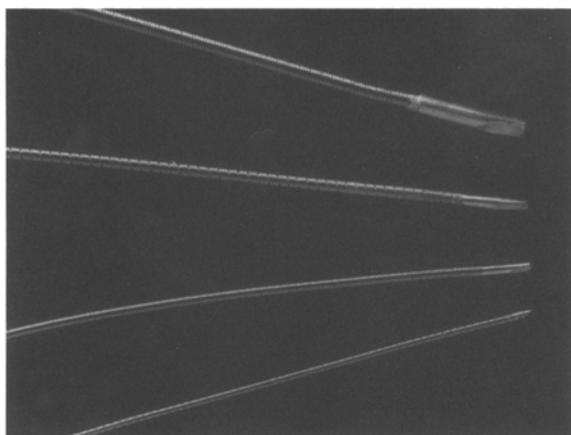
Ultrasound transducers are getting smaller. Top-bottom; 0.088" for 9F, 12.5 MHz catheter, 0.054" for 6F, 20 MHz, 0.042" for 4.8F, 20 MHz, and 0.031AI for 3.5F, 30 MHz.
